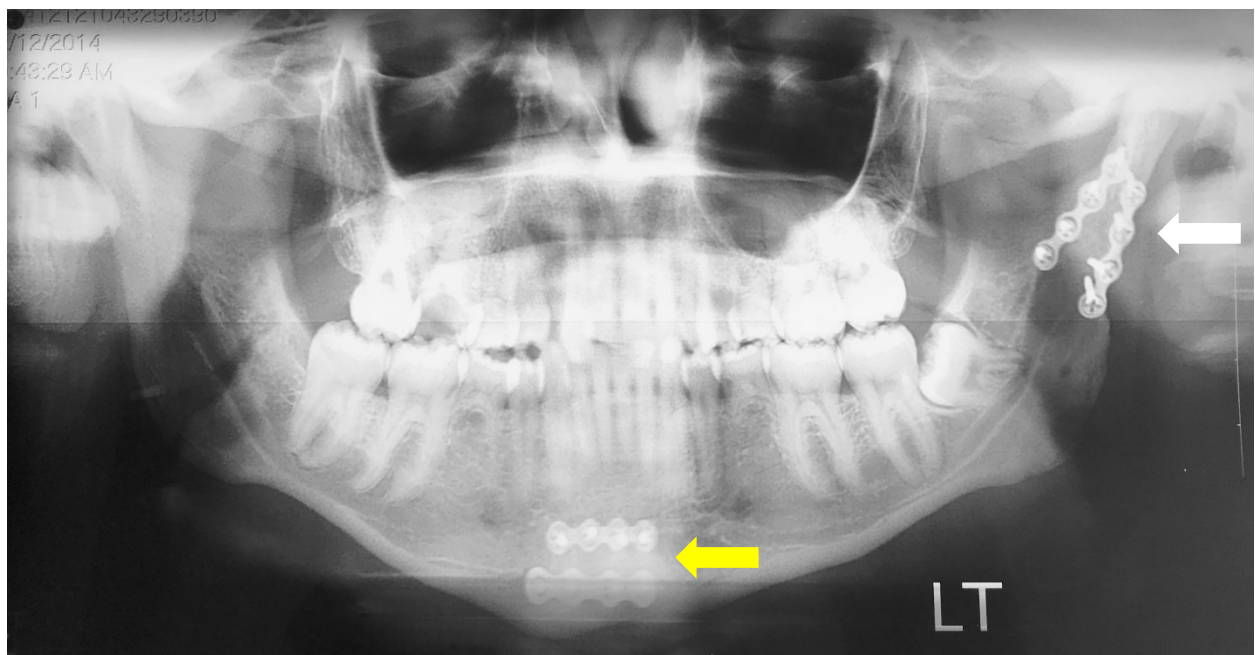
Panoramic X-ray showing two plates (white arrow) in the left condylar region. Also shown are two plates (yellow arrow) in the symphyseal region.
